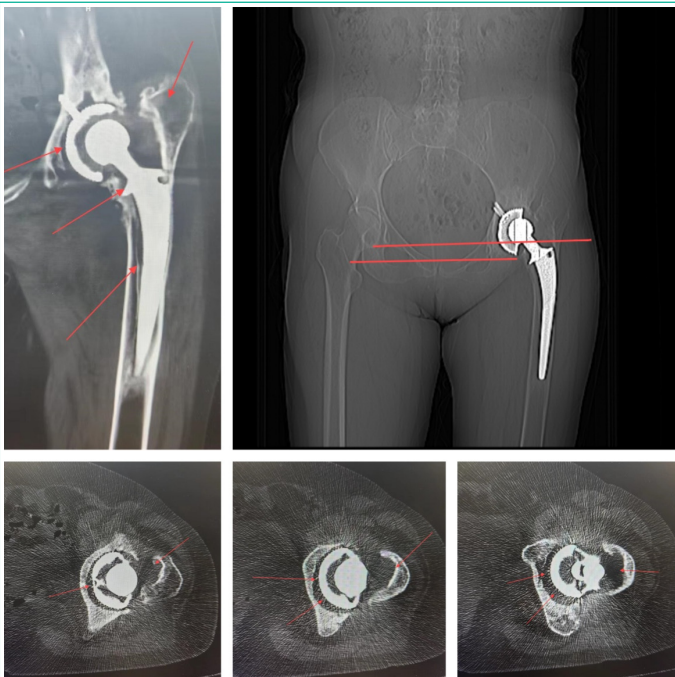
The CT scan demonstrated loosening of the left hip prosthesis, with superior displacement of the greater trochanter of femur and inferior displacement of the femoral stem.
